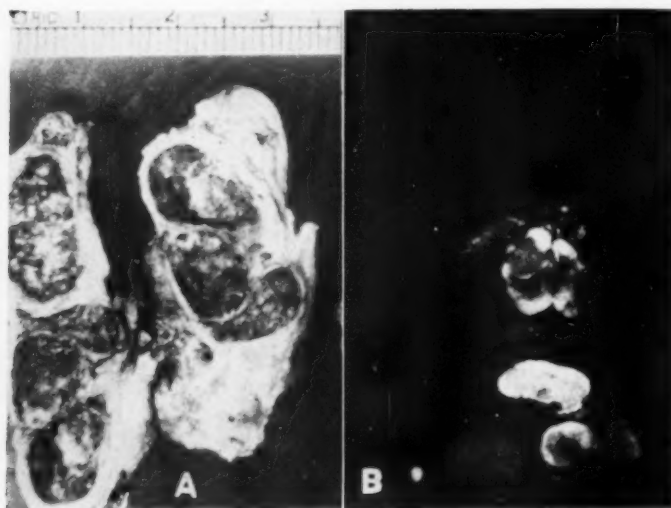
A. Transected mediastinal nodes. B. Roentgenograms of smaller nodes immersed in water.
